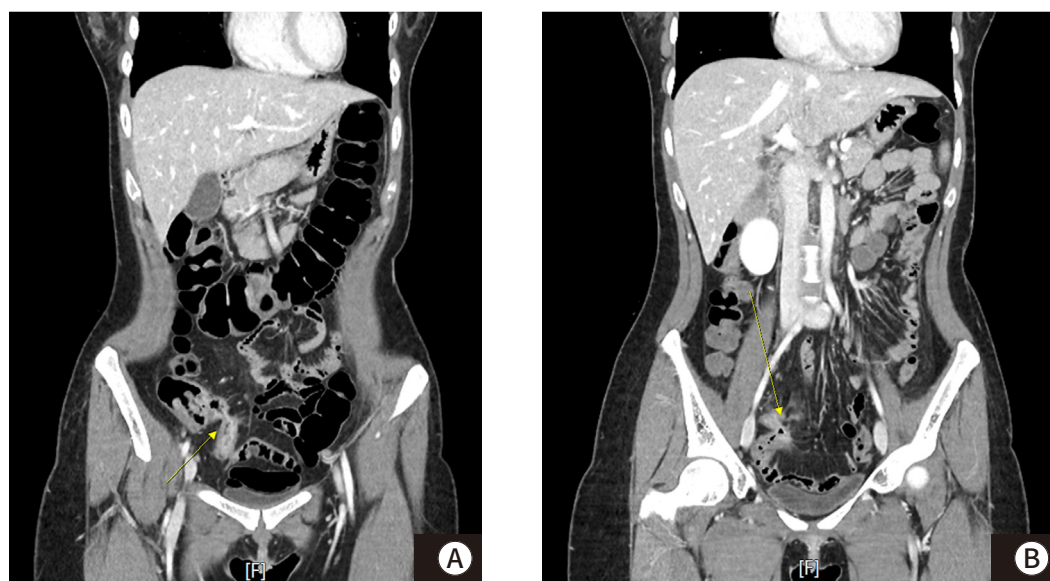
Contrast-enhanced CT image after conservative management for 2 weeks. (A) Contrast-enhanced CT clearly reveals entero-enteric fistula despite improvements in the inflammatory change in the ileum (B) another fistula tract is also observed clearly.
